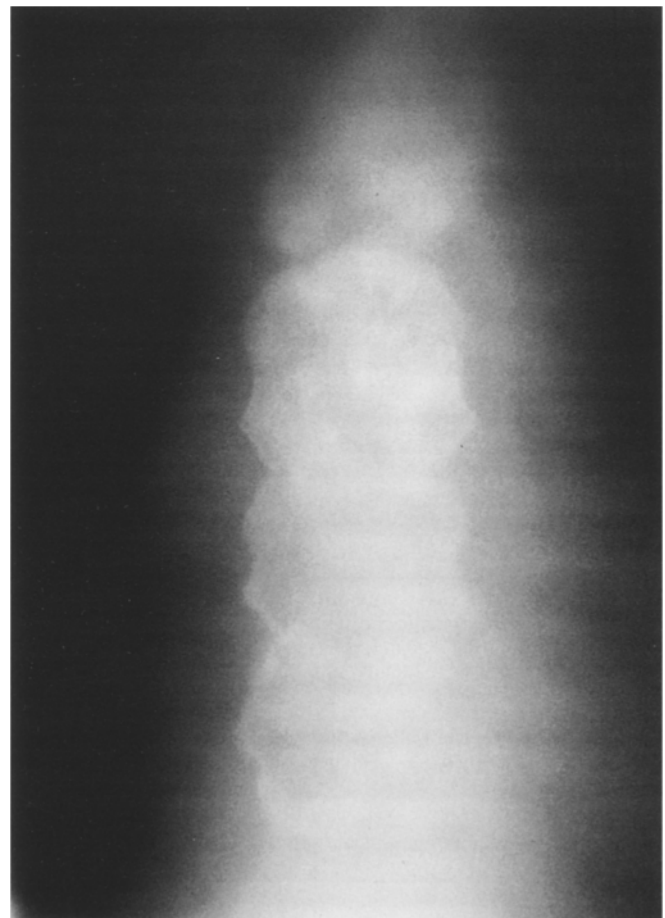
Roentgen tomography (case 2). Multiple osteolytic lesions of the sternum were notable
